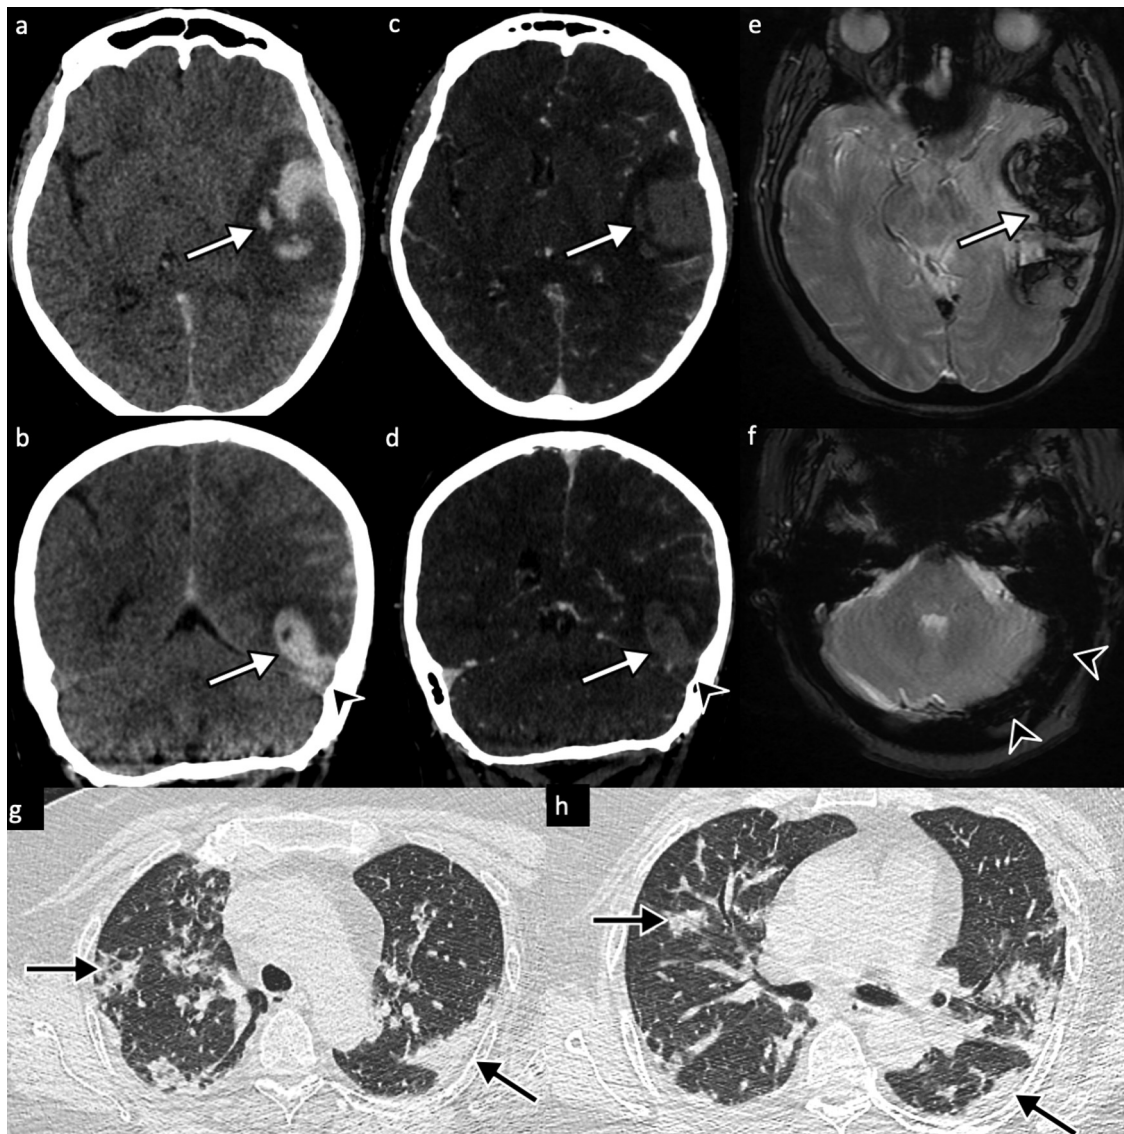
Patient 1. Non-contrast brain CT (a, b) revealed large confluent hyperdensity of the left fronto-temporal lobes (white arrows), consistent with intraparenchymal hemorrhage, as well as hyperdense left transverse sinus (black arrowhead), suggestive of cerebral venous thrombosis (CVT). CT venogram (c, d) demonstrated filling defect in the left transverse sinus, confirming CVT. Susceptibility-weighted MRI (e, f) showed loss of signal of the left fronto-temporal lobes (white arrow) and left transverse sinus (black arrowheads), confirming intraparenchymal hemorrhage complicating CVT. CT-scan (g, h) demonstrated bilateral areas of peripheral ground glass opacities and consolidations (black arrows), highly suggestive of COVID-19.
